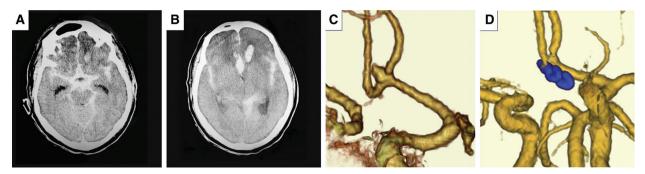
(A, B) Diffuse SAH was observed on head CT acquired at onset. (C) An approximately 3-mm anterior communicating artery aneurysm was present on preoperative 3D-CT angiography.
